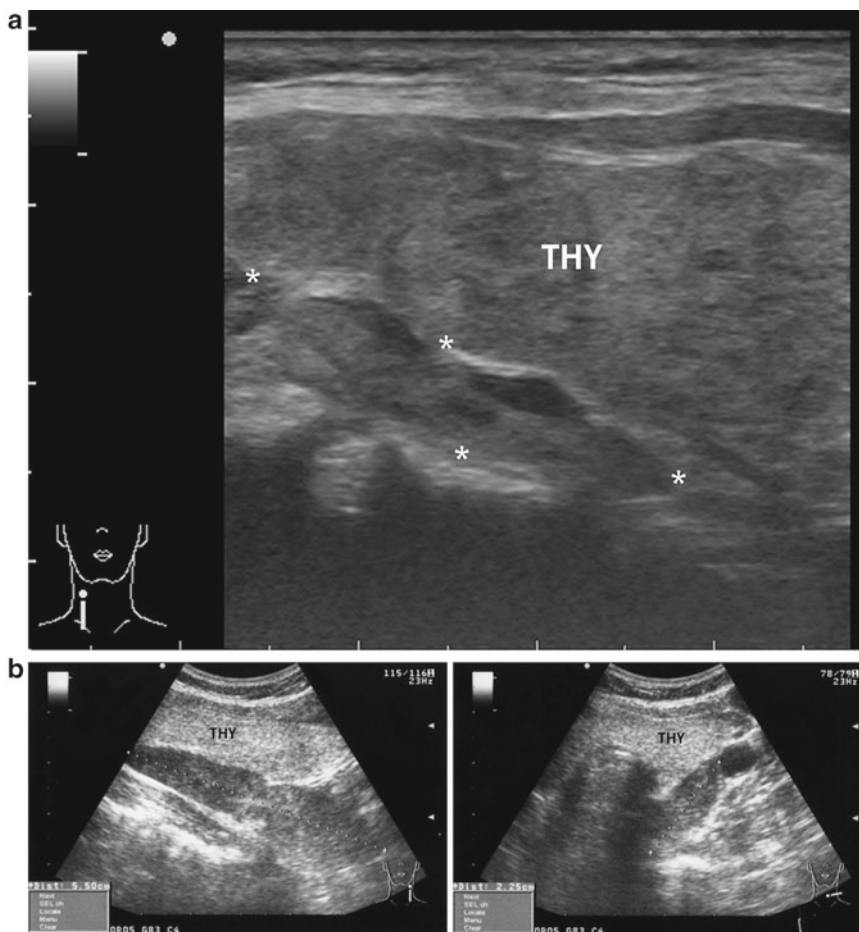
Variations of the sonographic appearance of abnormal parathyroid glands. (a) Enlarged parathyroid (*asterisks*) with knobby shape, texture isoechoic with the adjacent thyroid and cystic degeneration within the parathyroid tissue (*black areas*). This was imaged with a linear transducer probe. (b) Left upper parathyroid imaged longitudinally to measure nearly 6 cm and be larger than the thyroid (*left panel*) and imaged transversely (*right panel*) using a “fingertip” curvilinear probe. (c) Right superior parathyroid (*asterisks*) is shown, imaged longitudinally
